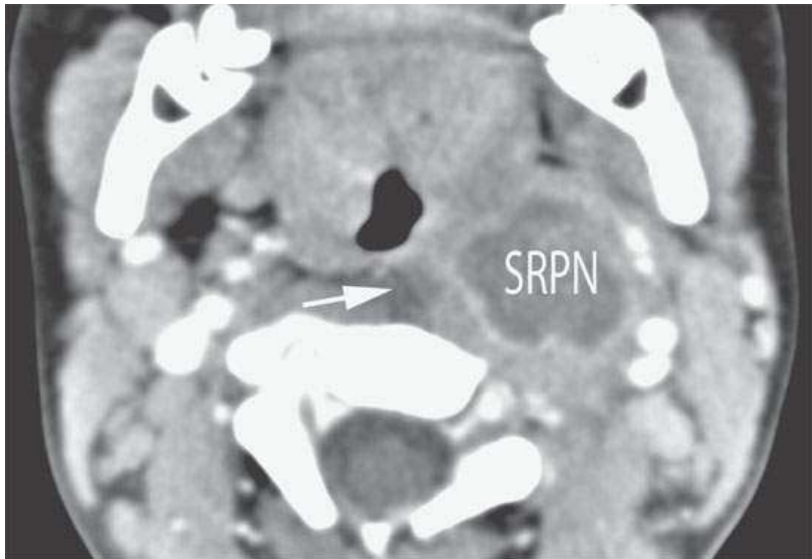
Contrast-enhanced computed tomography in a 1-year-old child with partially treated suppurative retropharyngeal adenitis. The suppurative node (*SRN*) has a minimally enhancing margin and relatively low grade surrounding inflammatory response and a small amount of retropharyngeal edema (*arrow*).
